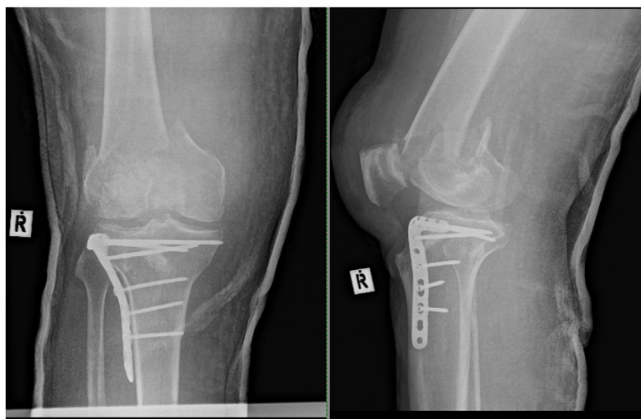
Pre-operative radiograph showing comminuted fracture supracondylar of right femur.
